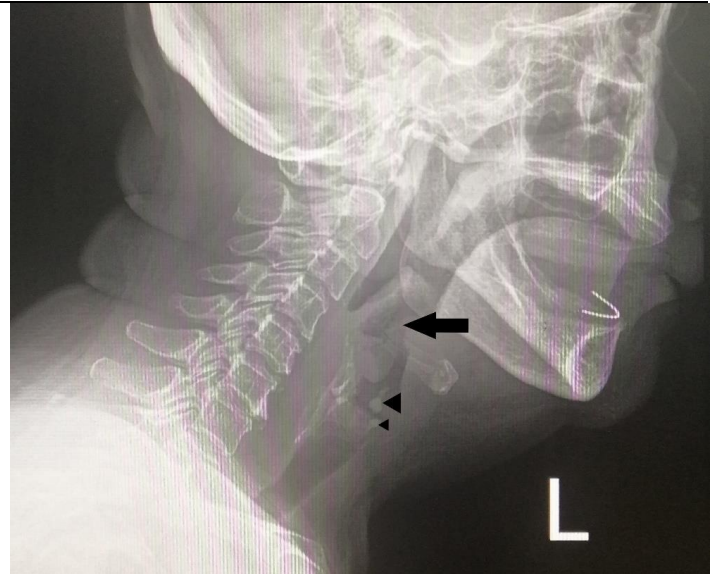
Lateral soft tissue neck X-ray shows a vague foreign body at the level of the hyoid bone, posterior to epiglottis which has mixed soft tissue density and radiolucent area (arrow). Another two foreign bodies appear like a teardrop, one above the vocal cord (big arrow head) and the other one below the vocal cord (small arrow head).
